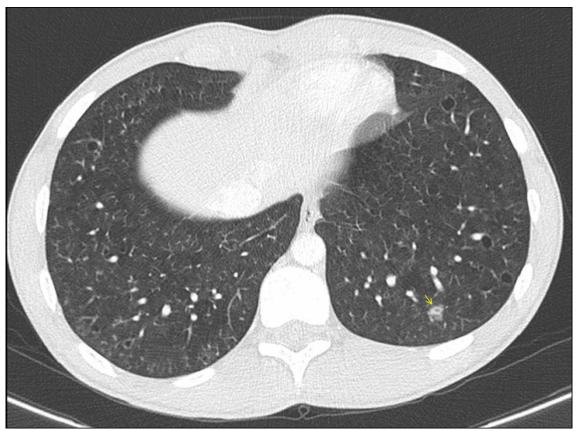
Axial high-resolution CT image (lung window) showing a solid peripheral nodule (arrow) with 13 mm, in the left lung base with irregular margins and central cavitation. The surrounding lung parenchyma appears normal.
